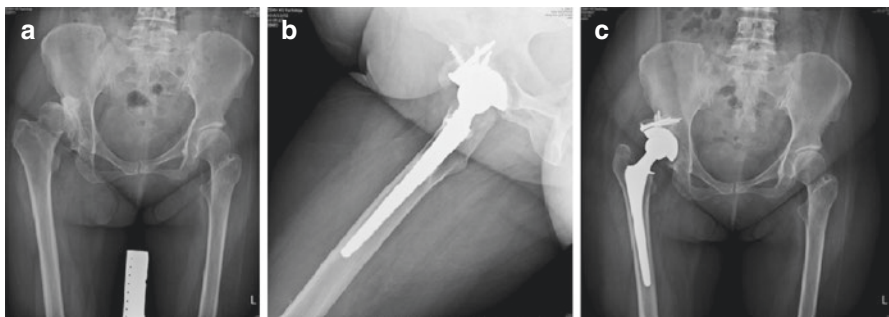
A Crowe type III DDH with severe arthritis in a 43-year-old woman (a). Radiograph taken 1 year after THA with autograft augmentation of the superior deficiency (b and c) (these pictures were agreed by the patient for publication)
